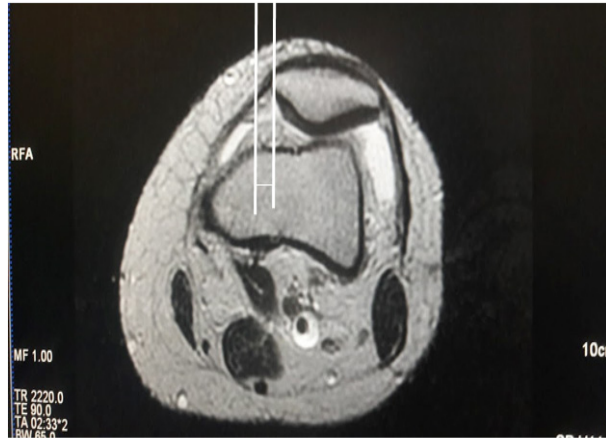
T2W axial MRI image showing lateral patellar subluxation. It is measured by distance between the line perpendicularly drawn to the medial corner of the patella and the line perpendicularly drawn to the most anterior segment of the medial femoral condyle.
